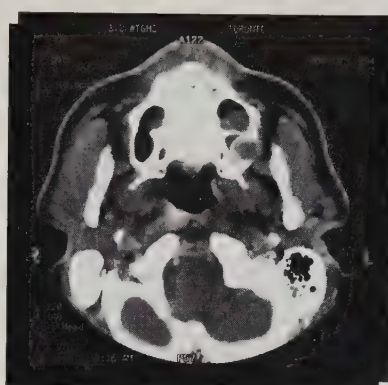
Axial CT scan shows the perforation of the left lateral maxillary alveolus and the expansion of the sinus floor.
